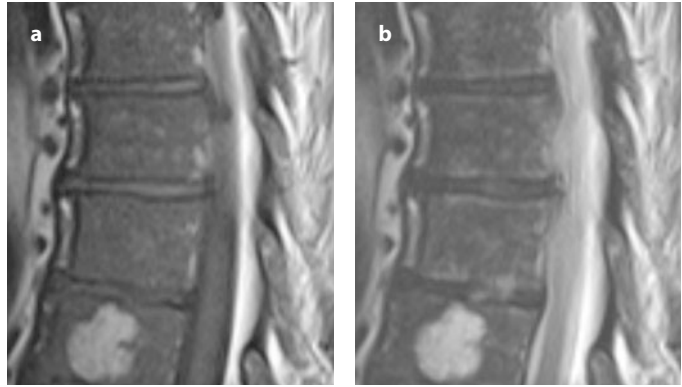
Sagittal T1-weighted (a) and T2-weighted (b) as well as axial T2-weighted (c) MRI demonstrating a large hemangioma in the L3 vertebral body extending into the left pedicle. It presented as punctate areas of low or isointense signals compared with bone on T1-weighted MRI and high signal intensity on T2-weighted MRI
